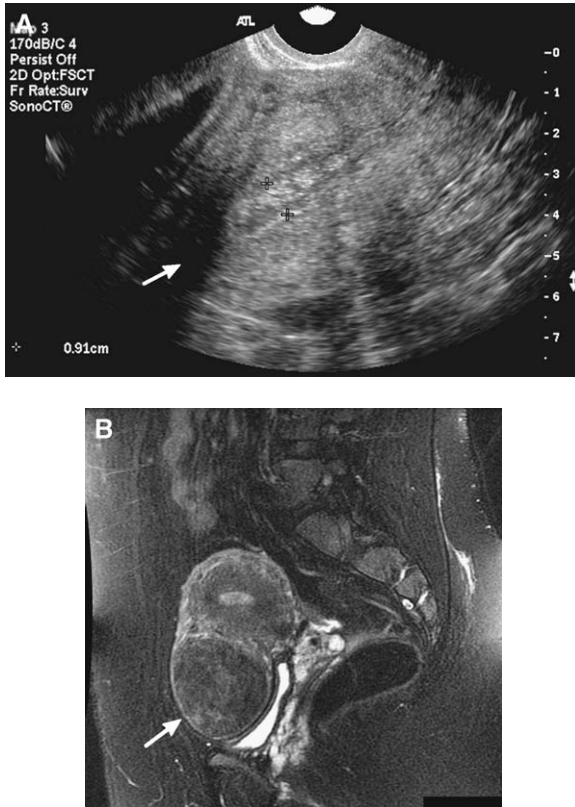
(A) TVUS does not demonstrate a subserosal fibroid adequately (arrow). (B) Sagittal T2-weighted MRI demonstrates large subserosal fibroid (arrow) emanating from the anterior wall of the uterus. Note the bladder compressed posteriorly.
